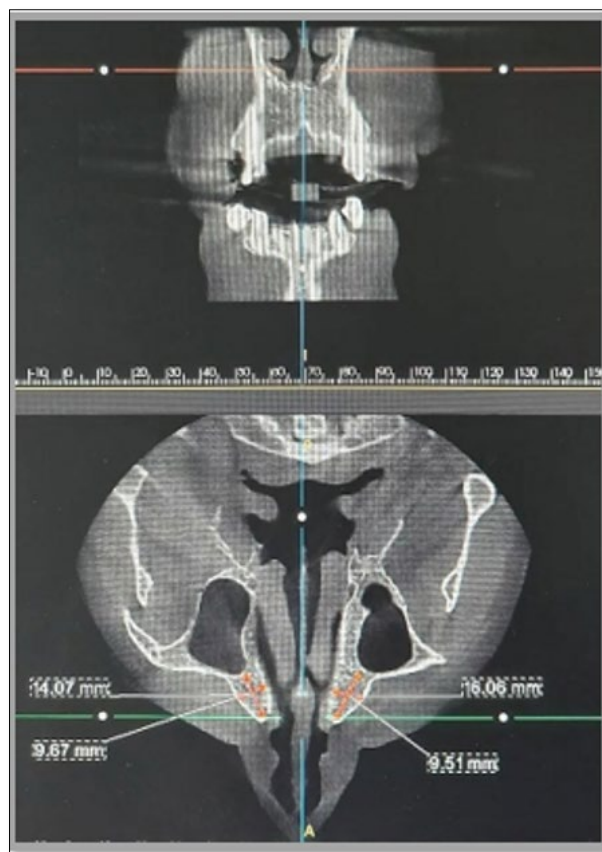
CBCT assessment of the frontonaso-vestibulo-sinus region.
